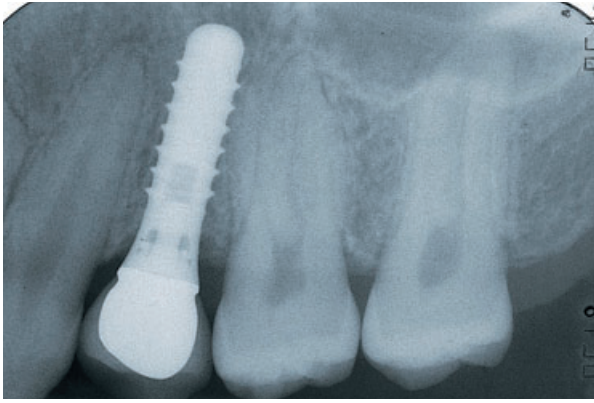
Similar findings are present in the corresponding left-sided follow-up radiograph.
